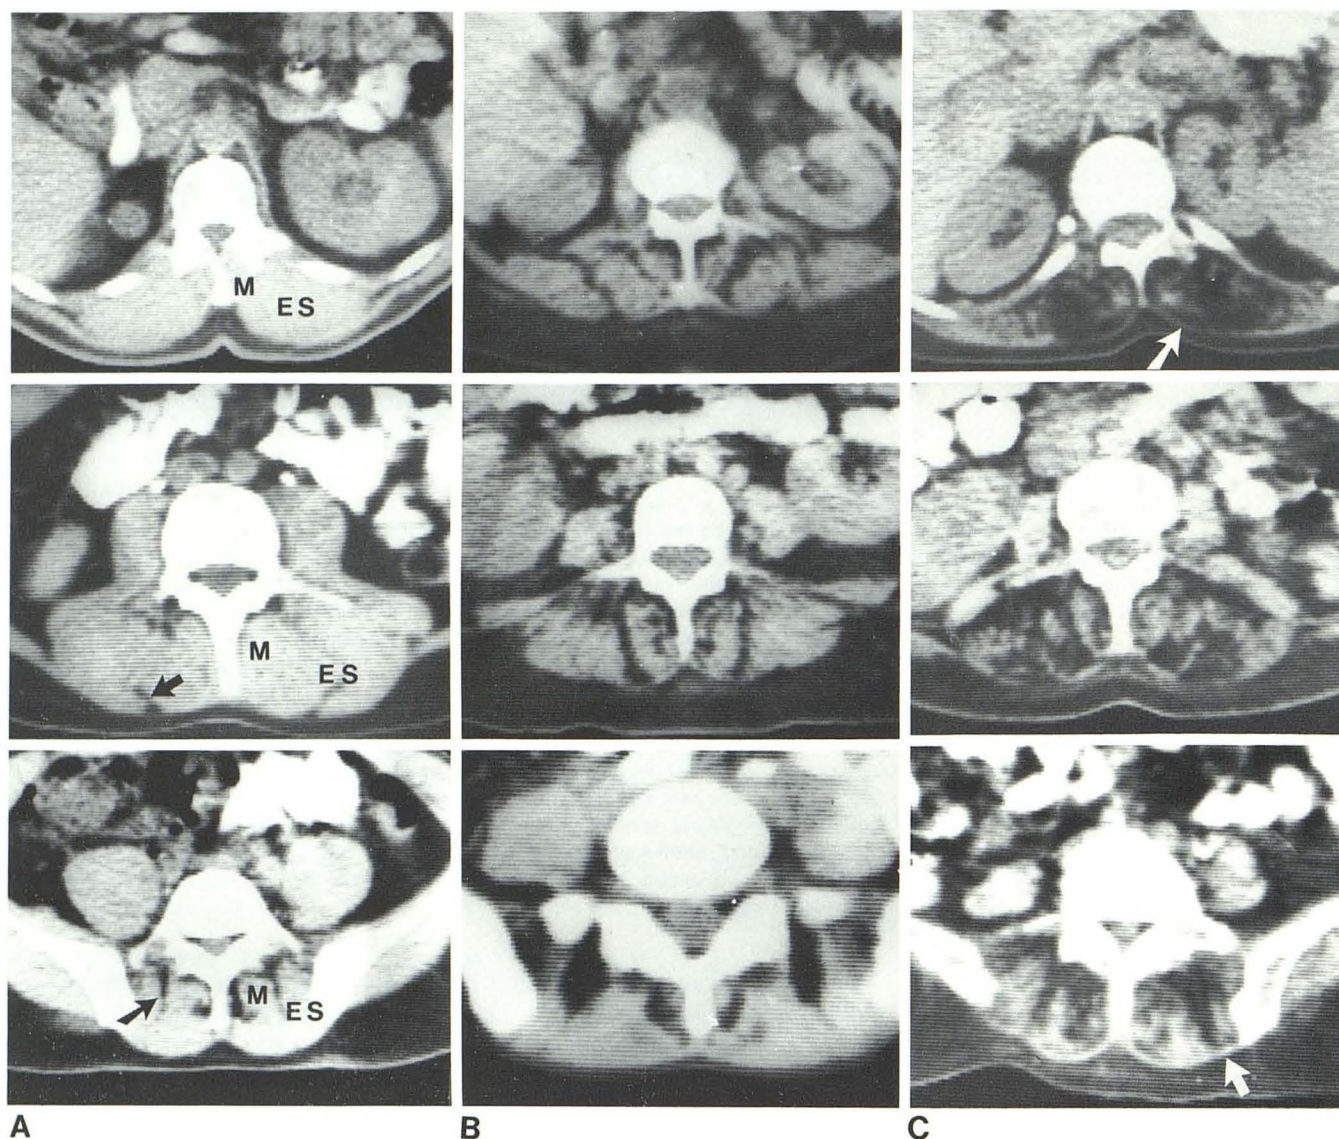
CT scans at three levels. Level 1 (top row); levels 2 and 3 (middle and bottom rows, respectively). A, Grade 0 fatty changes. Paraspinal muscles appear dense and homogeneous; fine, low-density striae separate muscle bundles (arrows). B, Grade 1 changes. Slight decrease of paraspinal mass
